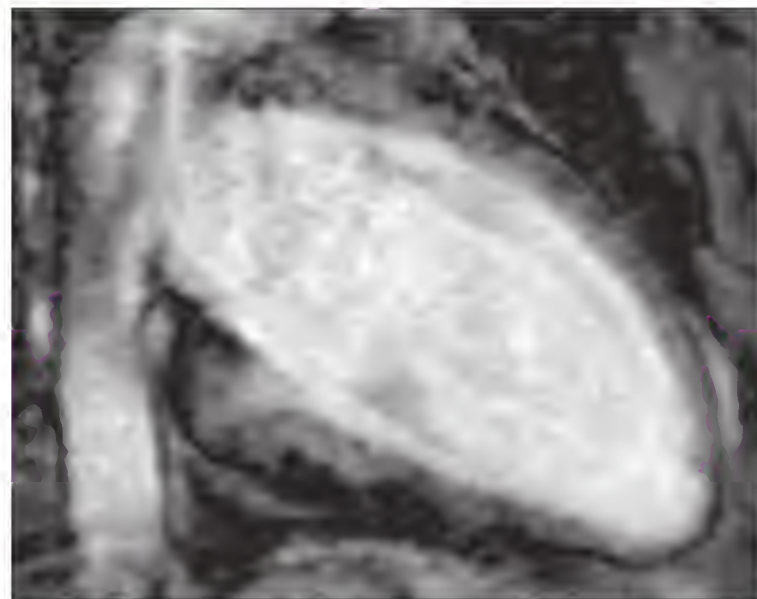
Extensive diffuse myocardial edema in a patient with sarcoid-associated acute myocarditis. Cardiac magnetic resonance image showing late gadolinium enhancement (mottled gray appearance of left ventricular myocardium).
